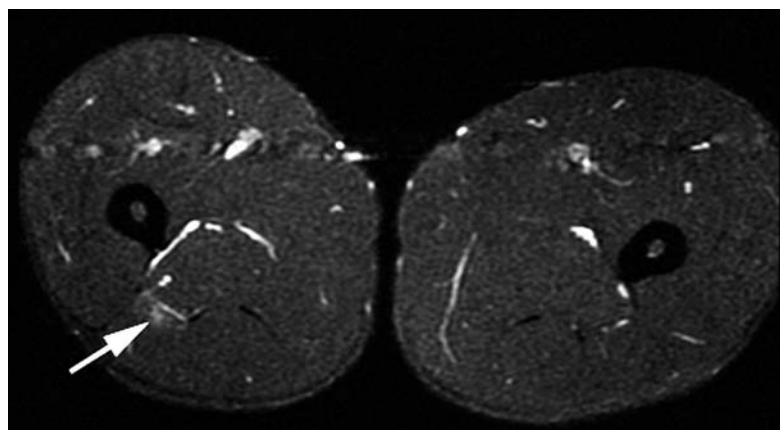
Professional footballer with acute onset thigh pain. Axial T2-weighted fat suppressed MR image shows minor area of edema (arrow) within the long head of biceps femoris (grade 1 injury)
